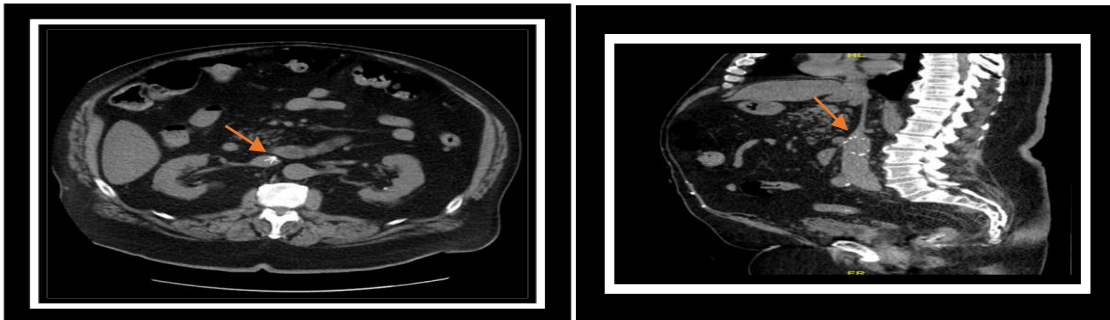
CT abdomen and pelvis without contrast demonstrated location of the IVC filter below the level of renal veins.
